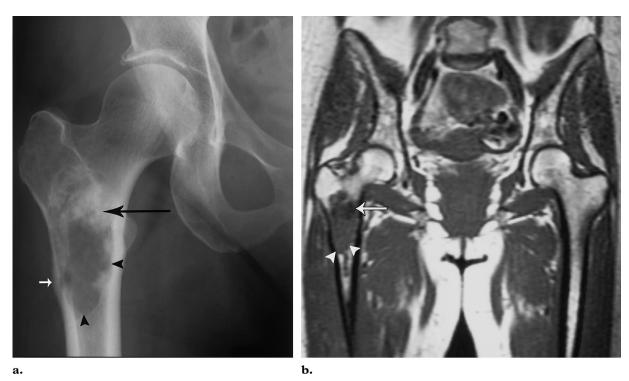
(a) Radiograph demonstrates a subtrochanteric lytic lesion in the right femur with cortical thickening (arrowheads), endosteal scalloping (small arrows), and chondroid matrix (large arrow), findings that are typical of chondrosarcoma. (b, c) Coronal T1-weighted (b) and axial T2-weighted (c) MR images help suggest a diagnosis of dedifferentiated chondrosarcoma by depicting a large softtissue mass (arrows) that was not detectable on the radiograph.
